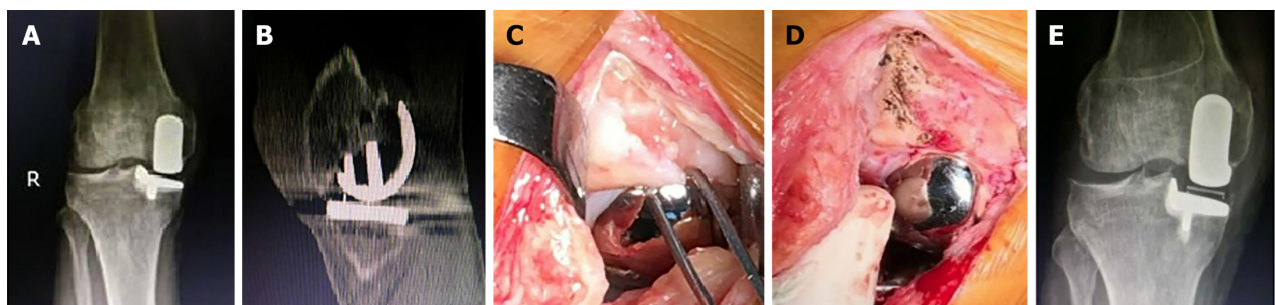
Treatment process (right knee) for Patient 3. A: Anteroposterior X-ray before revision; B: Dual computed tomography image showing osteophytes in front of the femoral prosthesis; C: Osteophytes in front of the femoral prosthesis; D: Excision of osteophytes; E: Anteroposterior X-ray after revision.
